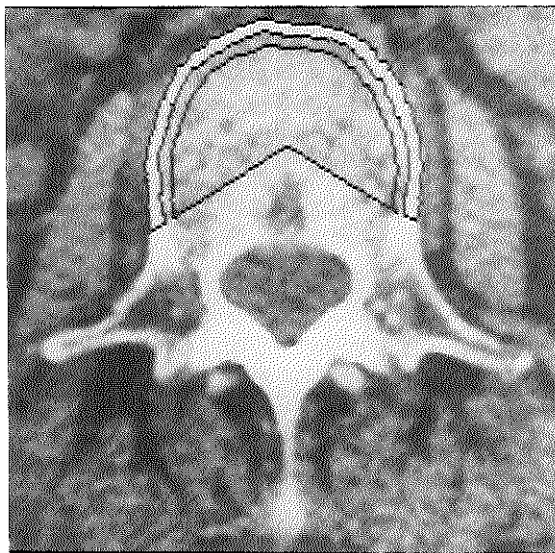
CT scan of L3 showing the cortical and trabecular ROI, respectively. For details see Materials and Methods.
